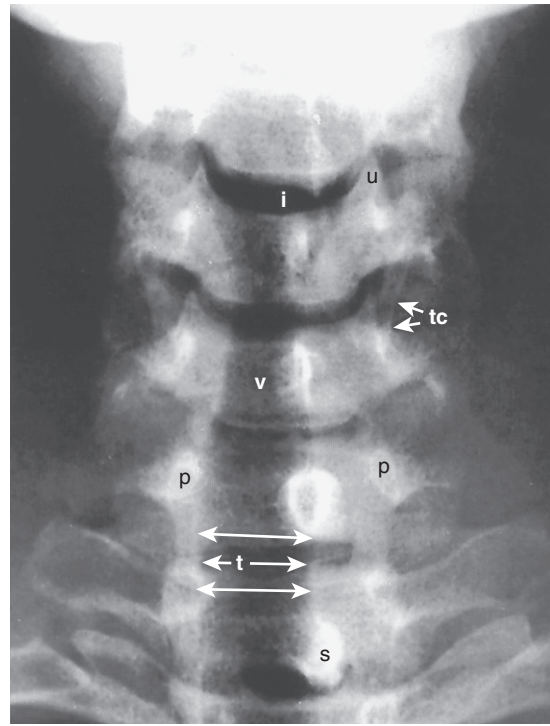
Anteroposterior radiograph of the normal cervical spine. i, Intervertebral foramen of C3–C4; p, pedicle of C6; s, spinous process of C7; t, trachea (arrows); tc, thyroid cartilage; u, uncinat process of C4; v, vertebral body of C5. (From Ovassapian A: *Fiberoptic Airway Endoscopy in Anesthesia and Critical Care*. New York, Raven Press, 1990, p 37.)
